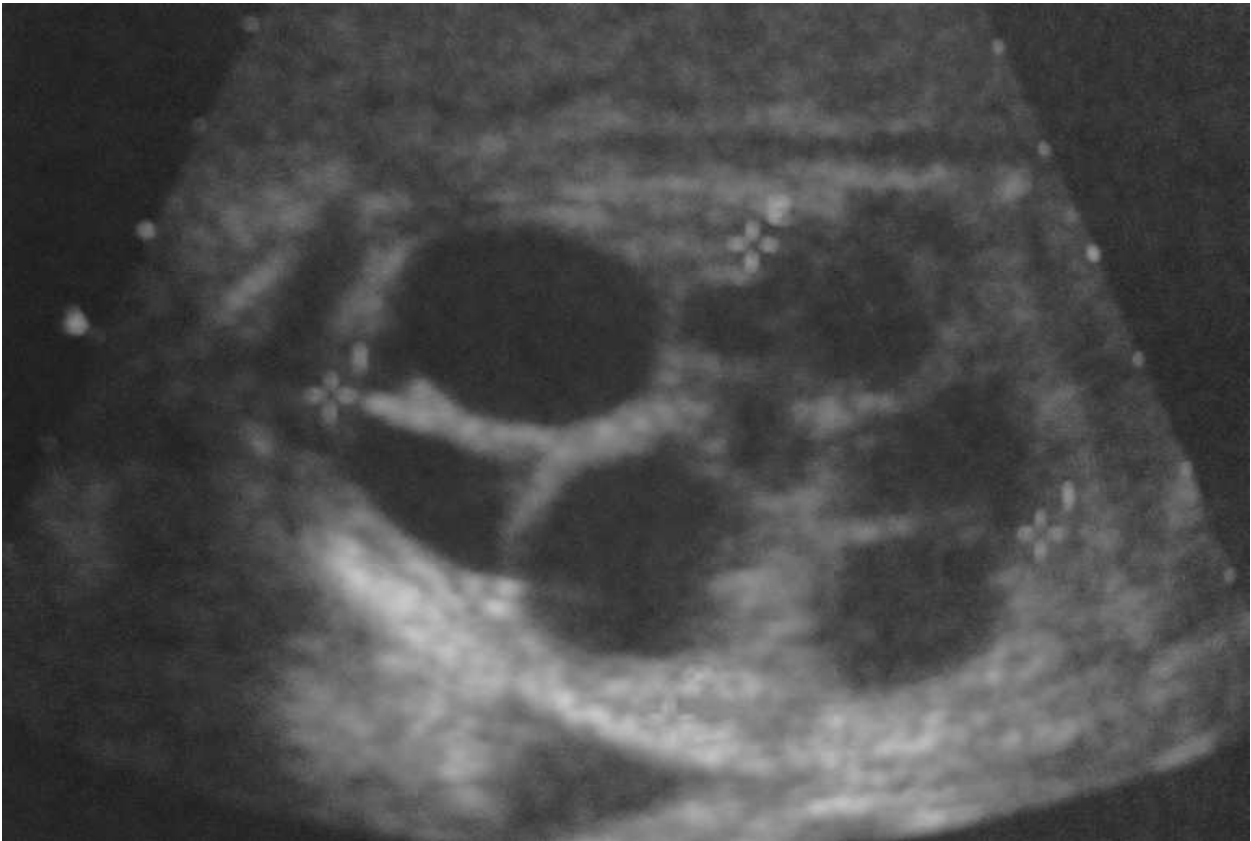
Prenatal sonographic diagnosis of M.C.D.K. (presence of sharp interfaces between multiple, randomly arranged, and variable size cysts, the largest with nonmedial location; a lack of an identifiable renal sinus; and an absence of renal parenchyma).
